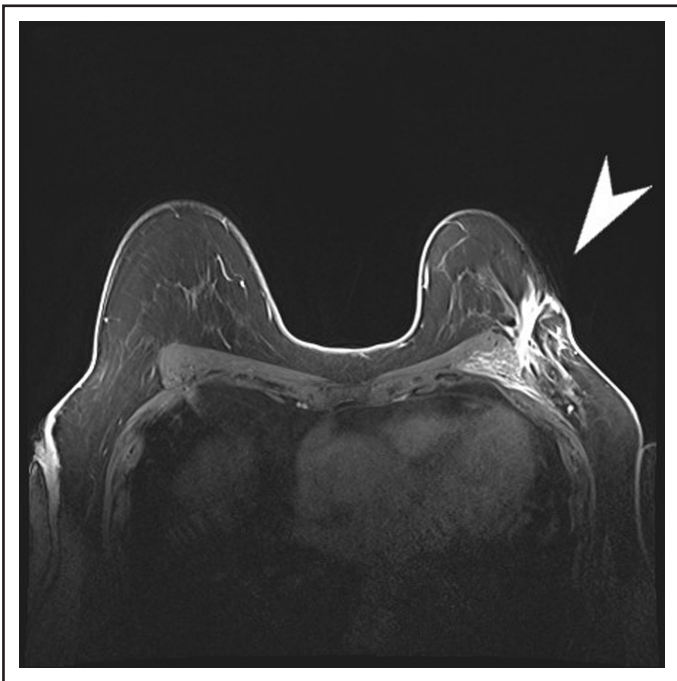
Delayed phase of post-gadolinium T1-weighted axial view; enhanced surgical scar and the abnormal area.
